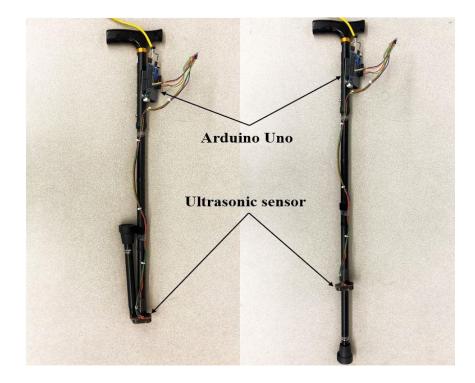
(Left) Folded and (right) unfolded physical cane with an Arduino Uno at the handle and an ultrasonic sensor at the bottom fold of the cane's shaft.
